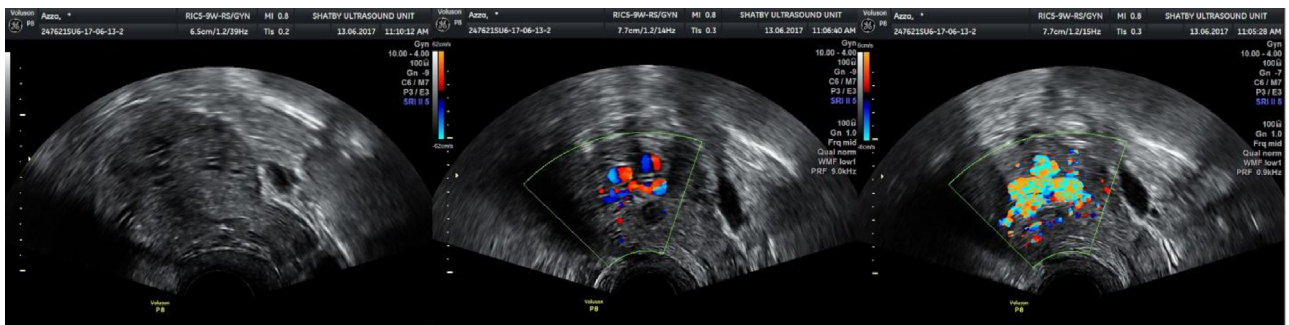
ultrasound two weeks postoperative revealed less dilated vessels intrauterine with low vascularity and intensity on Doppler scan.
